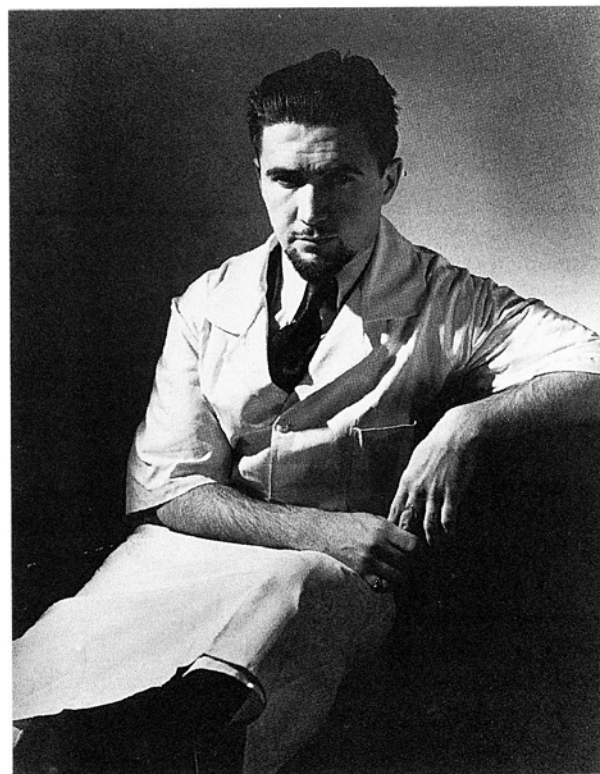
Assistant of the Department of Roentgentherapy of the Radium Institute of the University of Paris, 1936.
